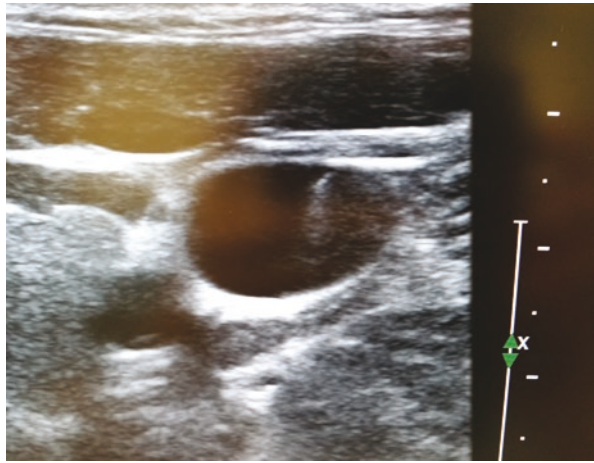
Ultrasound identifies guidewire in the RIJ with the probe head perpendicular to the vein and internal carotid artery
